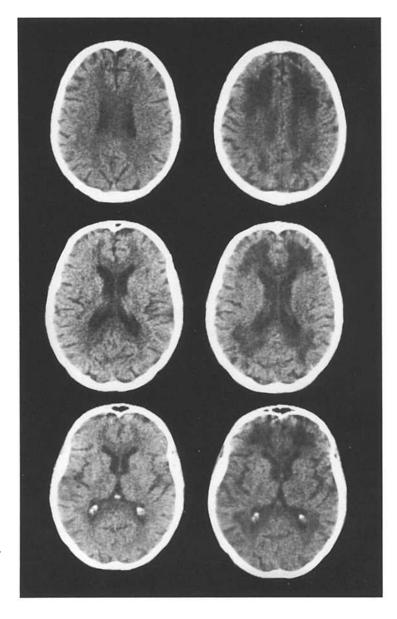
The first series of computed tomography scans (September 1985) is shown on the *left*. Note the moderate ill-defined hypodensities in the central hemispheric white matter. The corpus callosum is also involved and shows two small cysts in its central portion (middle). The second series (right) is from April 1986. The hypodense areas in the hemispheric white matter are now larger, more pronounced and well-defined. A cystic cavity is detectable in the centre of the callosal lesion
